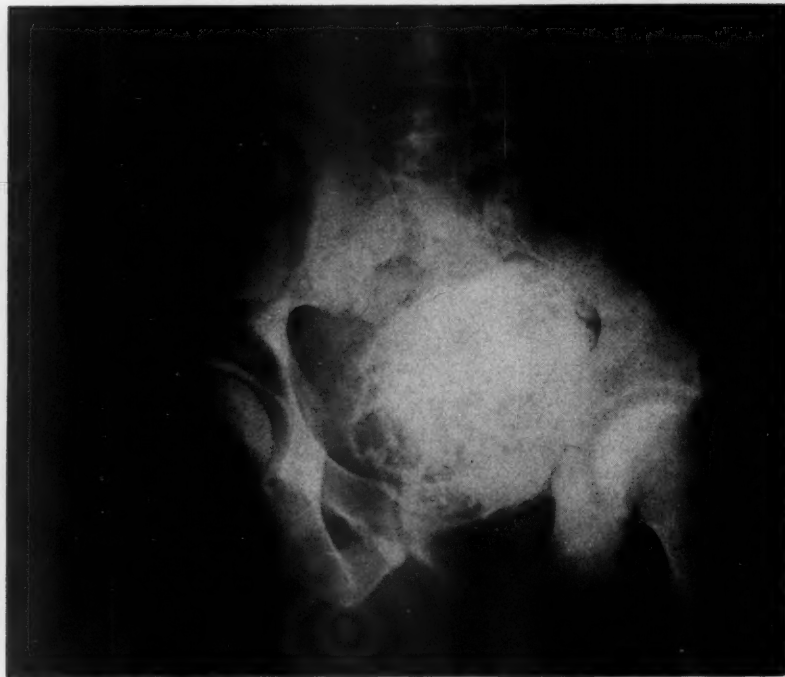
Anteroposterior roentgenogram of pelvis, showing the calcified tumor filling the entire pelvic space.
